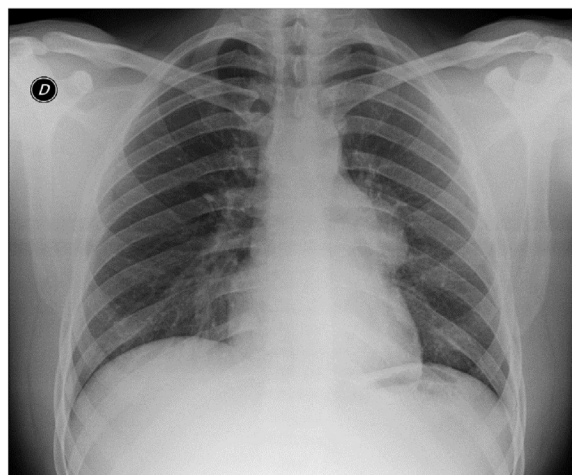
Standard thoracic X-ray: enlargement of the mediastinal opacity.
